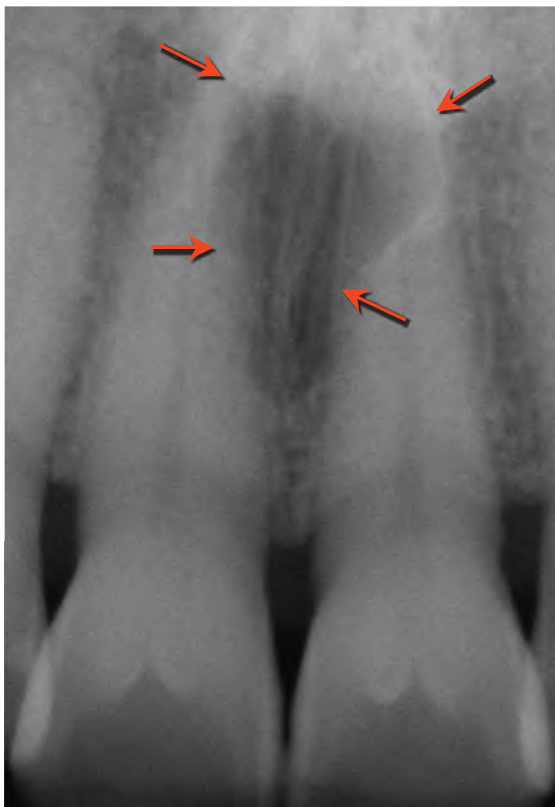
Periapical radiograph showing an *incisive canal cyst* (red arrows) also known as nasopalatine duct cyst. The midline location and relatively well-defined and symmetric appearance are highly suggestive of a developmental condition associated with normal anatomic structures in this region. These lesions are often described as “pear-shaped” or “heart-shaped” and are usually more than 6mm in diameter. (Courtesy of Dr. Parish P. Sedghizadeh, Los Angeles, CA.)
